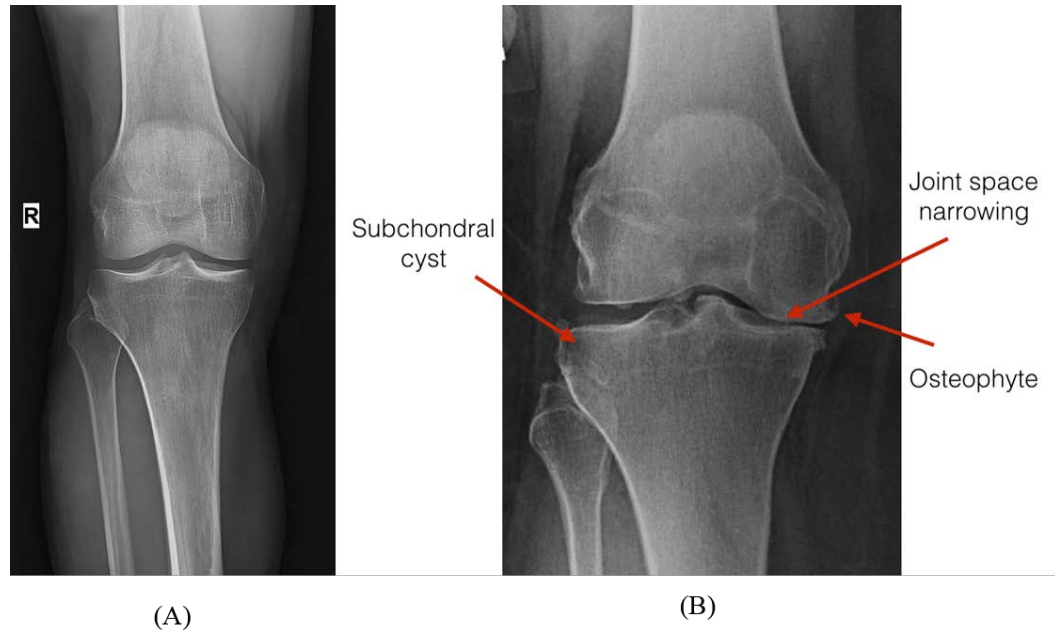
(A) An X-ray negative of a healthy knee can be easily distinguished from (B) an X-ray negative of an arthritic knee. In the arthritic knee the medial joint space compartment is severely narrowed, osteophytes (commonly called bone spurs) are present on the femoral condyles and patellar plateau, and a cyst has formed in the patella. (A) Open source image from [34]. (B) Used with permission from [35].
